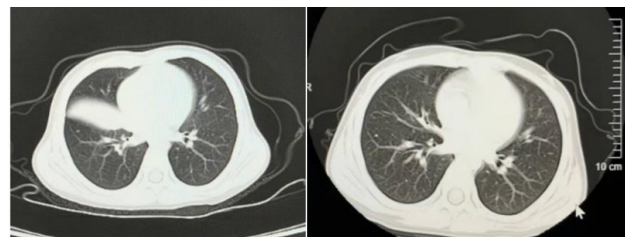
Imaging features of clinical cases A. CT image demonstrates that large patchy high-density shadow in right middle lobe; B. CT image demonstrates that few striped high-density shadows.
